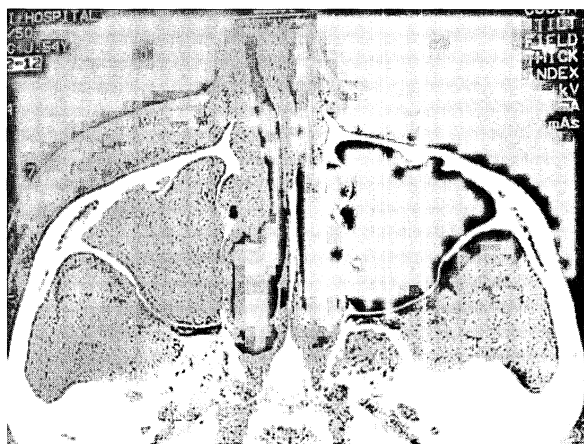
CT scan showing nearly total fluid filled at right maxillary sinus and little amount of air content
